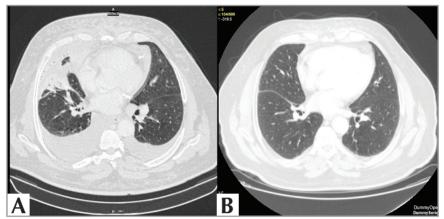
(A) Thorax computed tomography revealed pleural effusion and consolidations. (B) After completing 6 cycles of chemotherapy, complete remission was obtained.
